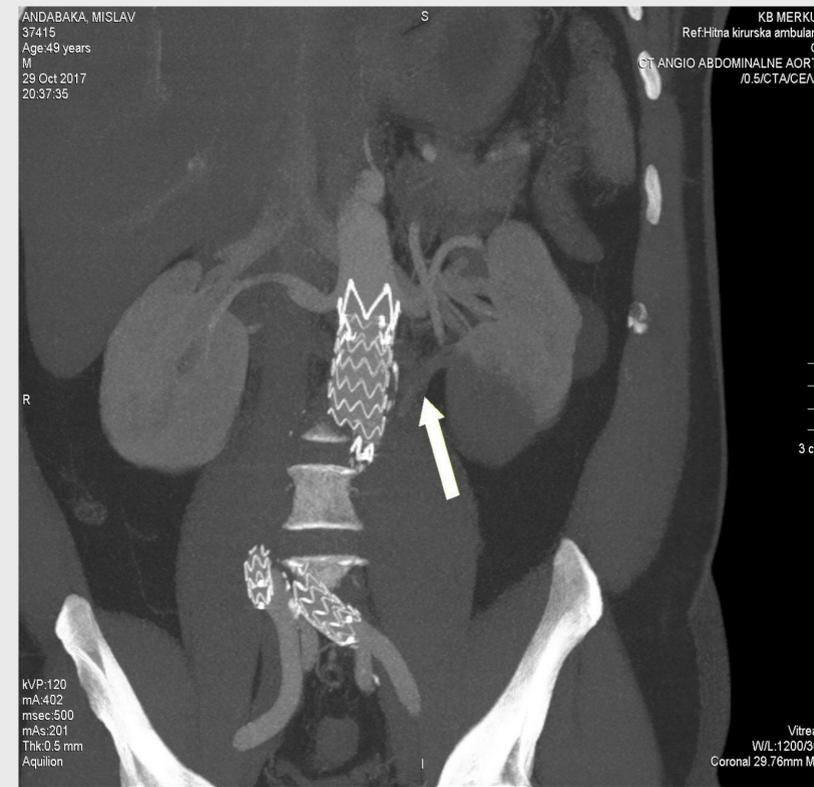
A contrast enhanced computed tomography (CT) one month before renal ischemia (routine 12 month control)
